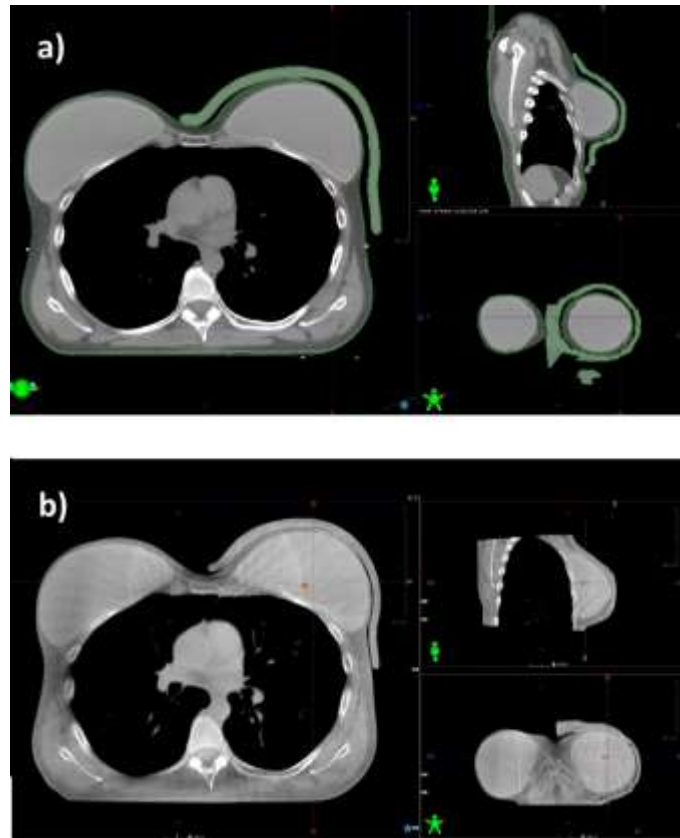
CT scan of a patient with prosthesis and standard gel bolus (a) and CBCT acquired before radiation delivery in the same patient (b). 3D bolus fits the skin without relevant air gaps.
